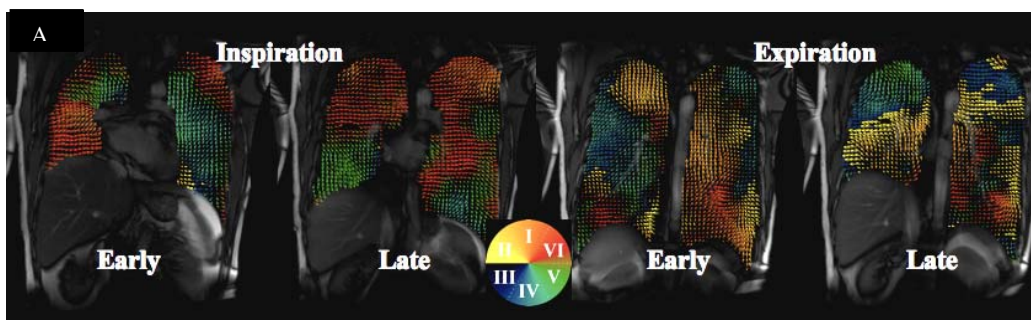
Representative coronal MR images superimposed with displacement field vectors in the right decubitus posture at four respiratory phases. Note each vector shows the magnitude of the displacement (length) and is colored depending on its displacement angle as described in the color scal.
